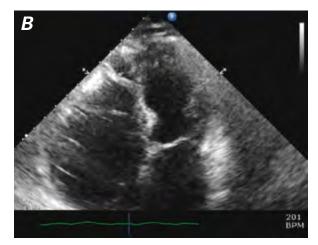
Post-cardioversion echocardiogram (apical 4-chamber view) shows a ballooning appearance of the left ventricular apex in A) diastole and B) systole.
